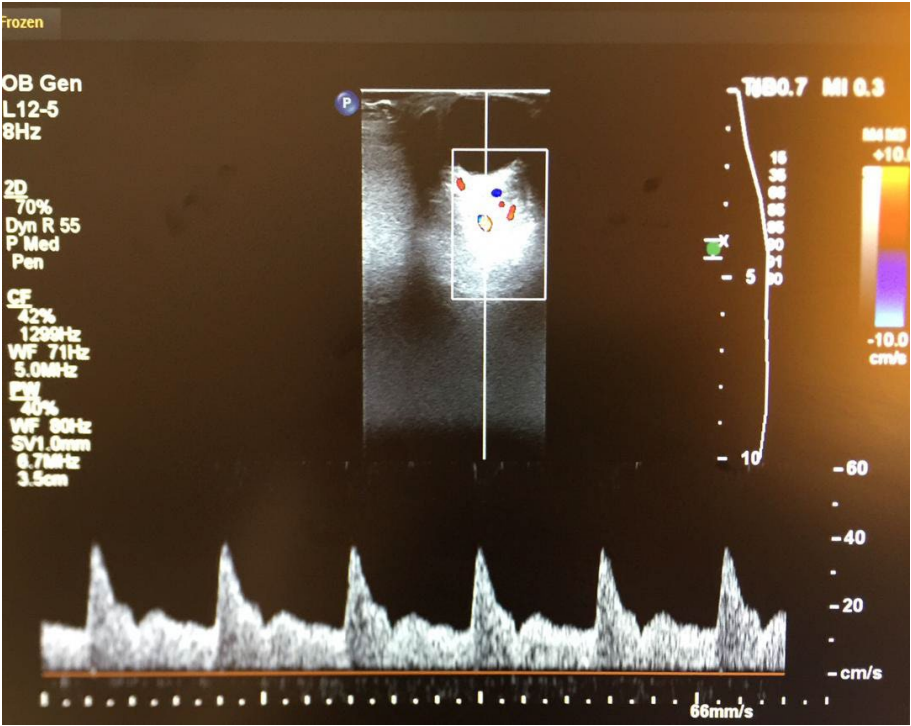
A sample of ophthalmic artery Doppler waveforms
